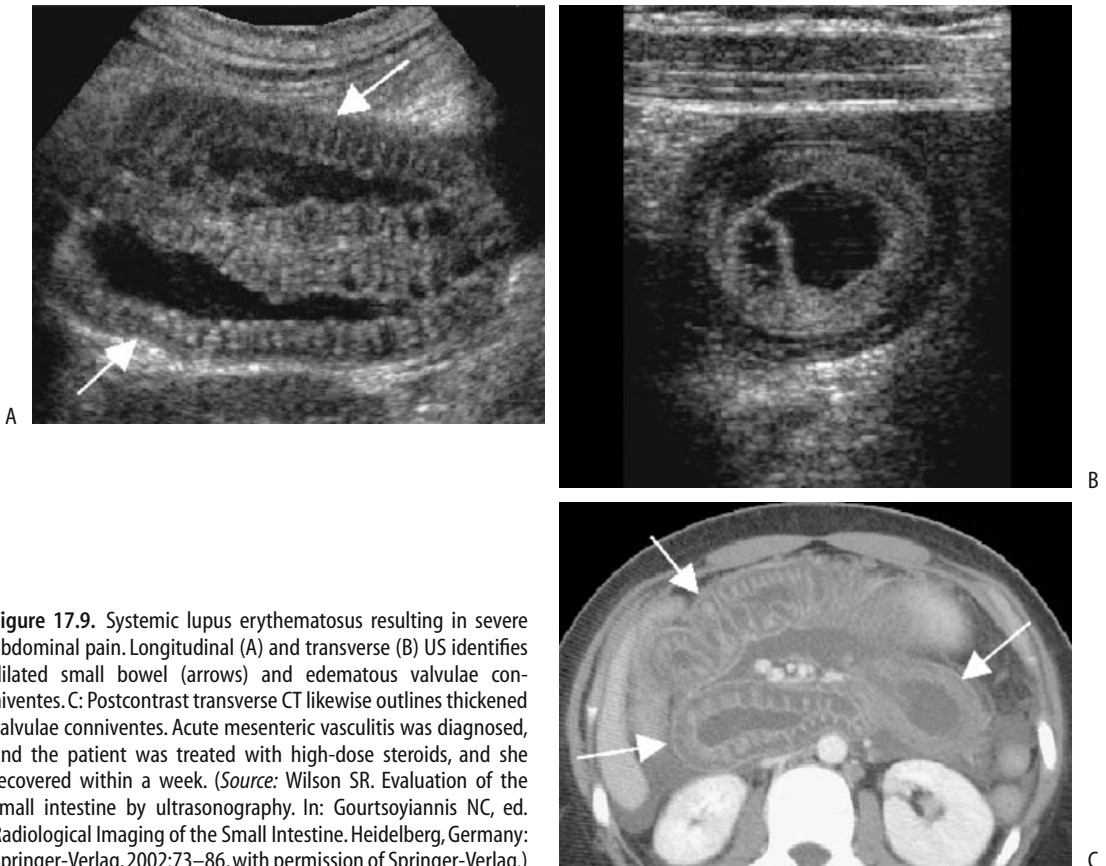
Systemic lupus erythematosus resulting in severe abdominal pain. Longitudinal (A) and transverse (B) US identifies dilated small bowel (arrows) and edematous valvulae conniventes. C: Postcontrast transverse CT likewise outlines thickened valvulae conniventes. Acute mesenteric vasculitis was diagnosed, and the patient was treated with high-dose steroids, and she recovered within a week. (Source: Wilson SR. Evaluation of the small intestine by ultrasonography. In: Gourtsoyiannis NC, ed. Radiological Imaging of the Small Intestine. Heidelberg, Germany: Springer-Verlag, 2002:73–86, with permission of Springer-Verlag.)
